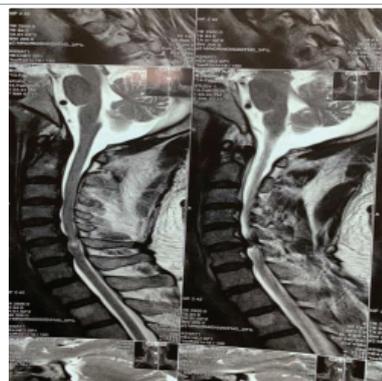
MRI cervical spine showing hyper intense lesion at C5/6 level.
